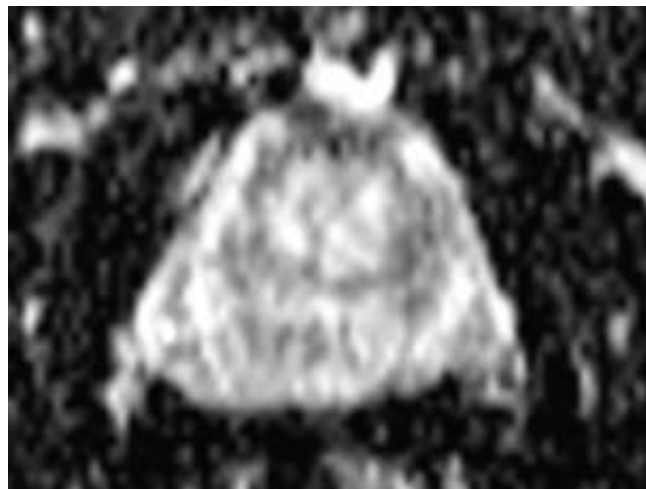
a DWI & 10.b ADC :Patchy moderate hyperintense changes in both peripheral zones (right slightly more than left) on DWI, which are moderately hypointense on ADC categorized as PIRADS III in peripheral zone.
